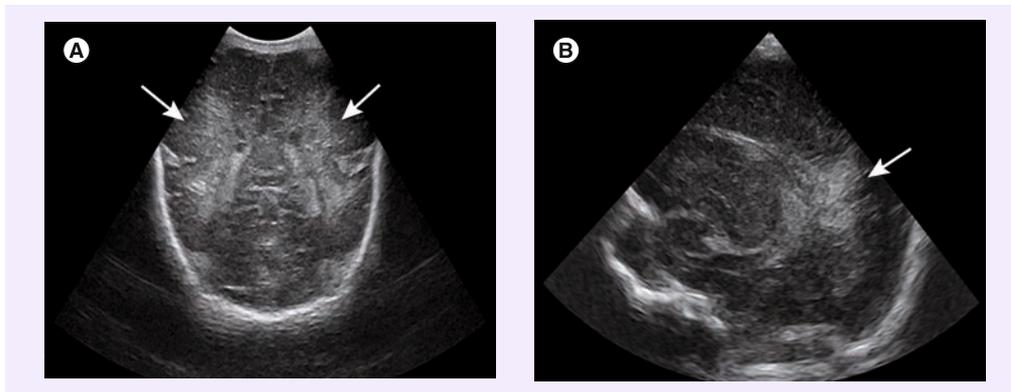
White matter injury on cranial ultrasonography. (A) High echogenicity (arrows) of nonphysiological periventricular echodensities, as shown on a coronal image at the level of choroid plexus in the lateral ventricles in a preterm infant with a gestational age of 31 weeks. (B) Sagittal view in the same infant showing inhomogeneous periventricular echodensities in the parietal white matter (arrow).
